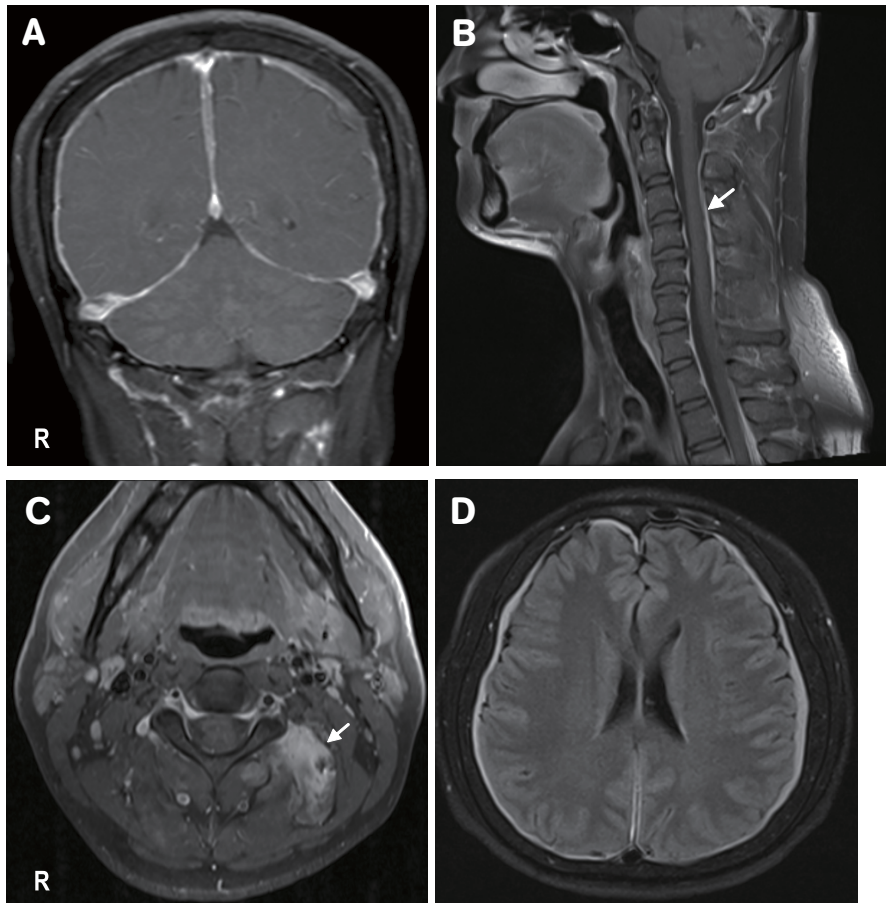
T1-weighted brain magnetic resonance image (MRI) in the coronal view with gadolinium enhancement shows diffuse pachymeningeal enhancement (A). T1-weighted spinal MRI in the sagittal view with enhancement shows ventral and dorsal dural enhancement (B, indicated by the white arrow). Spinal MRI in the axial view shows the paraspinous soft tissue enhanced lesion on the left side in the C1-C2 area (C, indicated by the white arrow). Brain MRI on fluid-attenuated inversion recovery (FLAIR) image in the axial view shows diffuse pachymeningeal hyperintensity (D, indicated by white arrows).
